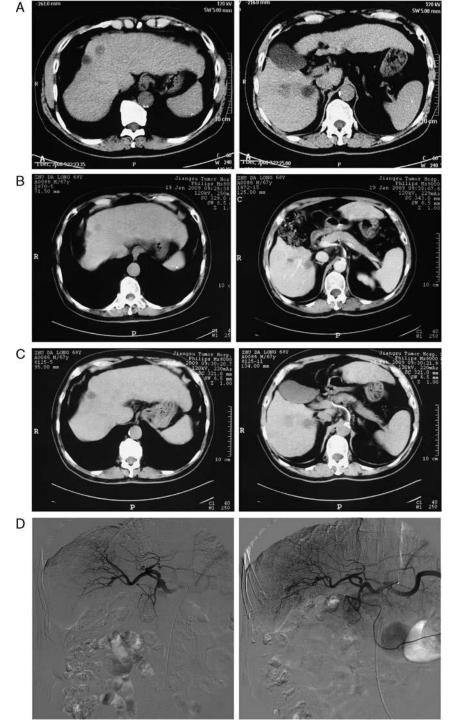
A to D, shows the result of 1 patient. A, A 68-year-old man was admitted to the hospital owing to a focal liver lesion for 14 days; AFP: > 363 ng/mL; diagnosis of CT: the lesion was considered as nodular HCC. The larger lesion, 3.2 3.3 cm, located in the area of light hepatic lobe was near to the diaphragmatic dome. B, imaging of CT reexamination after 49 days. C, imaging of CT reexamination after 92 days. D, there were no significant progress of tumor size and no visible lesion in the liver according to the 2 photographs of DSA taken after the first implantation of the medicine box and second infusion therapy days. Note that there are 3 issues with CT imaging: (1) the selected lesion slice and time phase were not consistent with each other; (2) the time phases of enhancement scanning were not uniform; (3) the size of images in Figure 1A was different from that in Figures 1B and C. We considered no change of the lesion was observed; thus, we could judge the change of tumor lesion size according to the findings of DSA. The patient probably had cholangiocellular carcinoma. CT indicates computed tomography; HCC, hepatocellular carcinoma.
